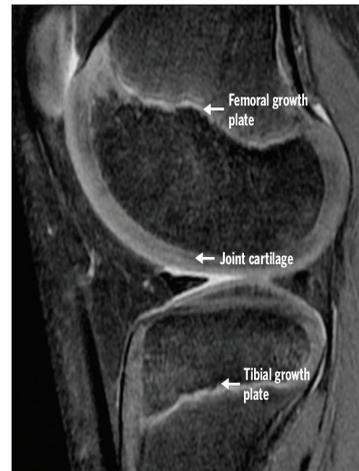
Magnetic resonance image showing thick cartilage without subchondral ossification and wide, open growth plates in a skeletally immature knee.
